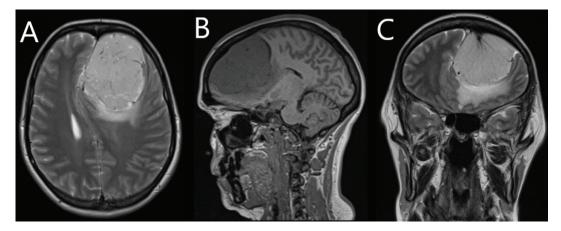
(A, B and C). Native brain MRI. Panel A shows an axial slice in T2 sequence from MRI of the brain showing hyperdense formation in the left frontal with dural tail and characteristic meningioma, perifocal cerebral edema and dislocation of midbrain structures. Panel C shows a T1 sequence of a frontally located hypodense formation in sagittal section. Panel C shows a coronal hyperdense image in T2 sequence through the meningioma shad
